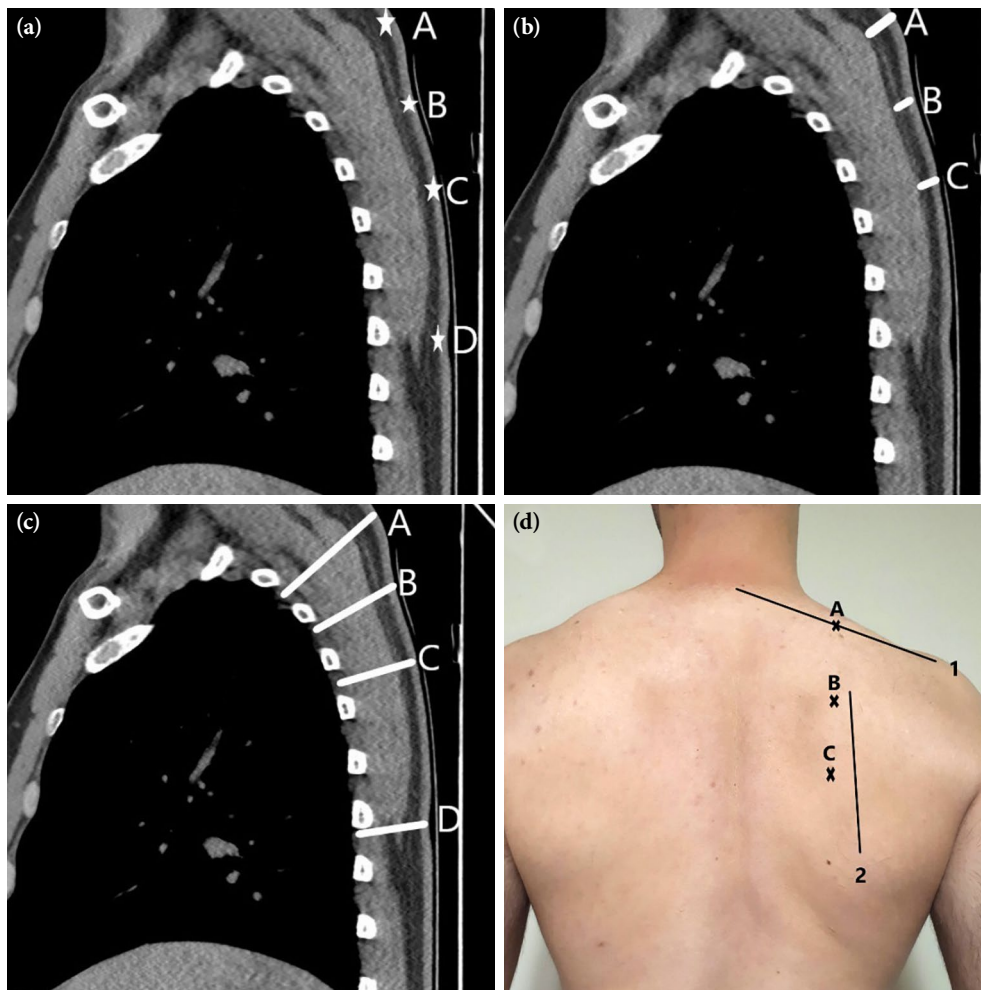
(a) Localizations of points A, B, C, and D on the chest CT image. (b) Distances from the skin to muscle at points A, B, and C. (c) Distances from the skin to pleura at points A, B, C, and D. (d) The localization of points A, B, and C in the dorsal region are shown. Line 1 is the line connecting the acromion and the spinous process of the seventh cervical vertebra. Point A is the midpoint of this line and is the reference point for upper trapezius muscle injections. Line 2 represents the medial edge of the scapula. Point C is located 1 cm medial to the midpoint of line 2 and is the reference point for injections of the rhomboid major muscle. Point B is located at the midpoint of the line connecting points A and C.
